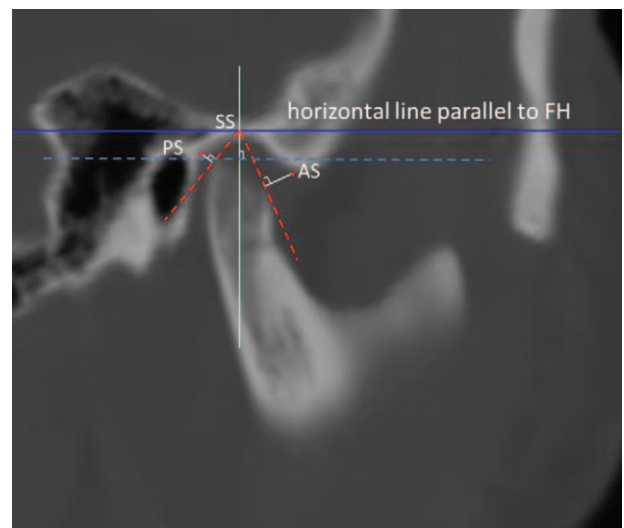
Linear measurements of the joint space in the sagittal CBCT view. Anterior joint space (AS), superior joint space (SS), and posterior joint space (PS) were measured according to the method of Cohlma et al.^[12] AS=anterior joint space, CBCT=cone-beam computed tomography, PS=posterior joint space, SS=superior joint space.
